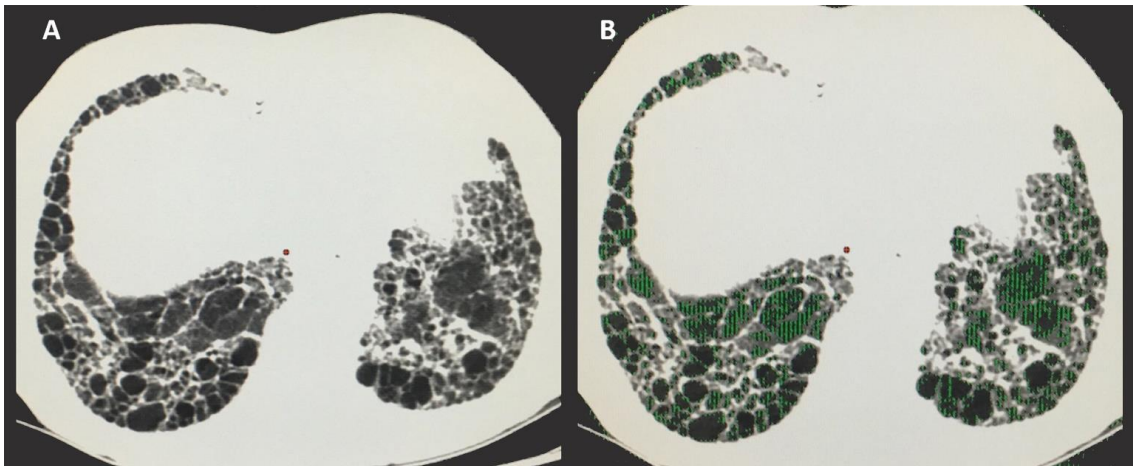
Expiratory HRCT from a subject with UIP pattern associated with air trapping.
